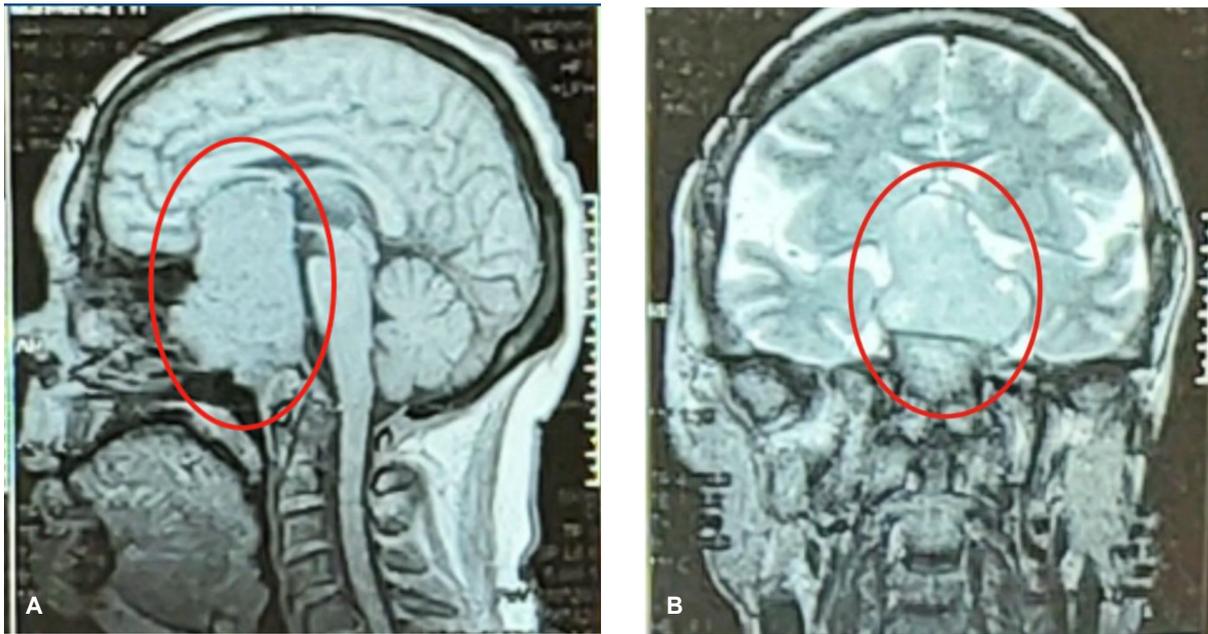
A giant invasive infrasellar/endosellar/suprasellar/parasellar/retrosellar pituitary adenoma in a female patient born in 1971. T1-weighted MRI, sagittal (A) and coronal (B) views.
